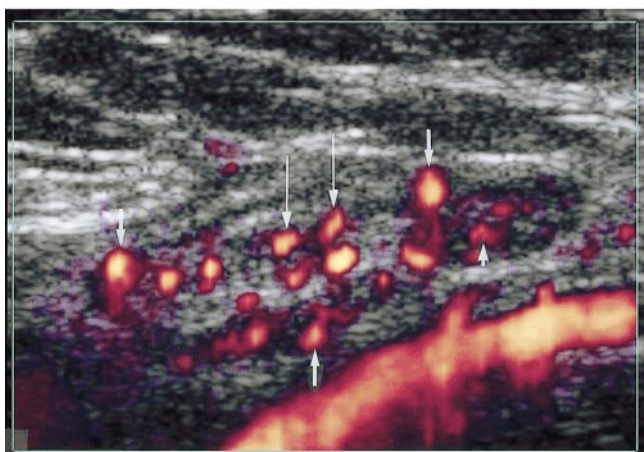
(a) Precontrast antiradial color power Doppler US image of a benign fibroadenoma shows sparse peripheral vessels (arrows). (b) Postcontrast antiradial color power Doppler US image of the same lesion as in a shows an increase in peripheral (long arrows) and central (short arrow) vessels.
